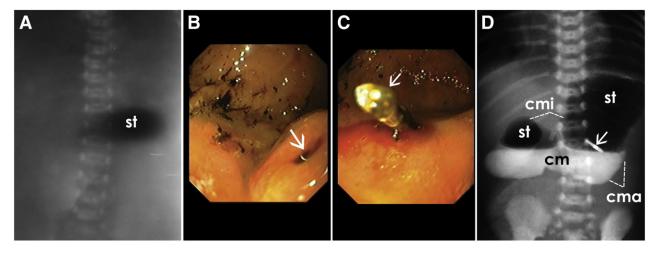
Radiographic (x-ray) and endoscopic appearance of a caliber-persistent artery on the greater curvature in the infant. A, The abdominal x-ray study of the pyloric atresia. Gas-filled stomach (st) and lack of gas in the intestines. B, Endoscopic image of a caliber-persistent artery (arrow) in the cardiac stomach wall taken on the fourth postnatal day. C, Endoscopic image on the closed artery. Arrow indicates the hemoclip. cmi indicates minor curvature; cma, major curvature. D, Upper gastrointestinal contrast study taken on the 28th postnatal day showing the accumulation of contrast material (cm) in the stomach (st). Arrow indicates a hemoclip, which has been introduced to stop bleeding from the caliber-persistant artery shown on panel B.
